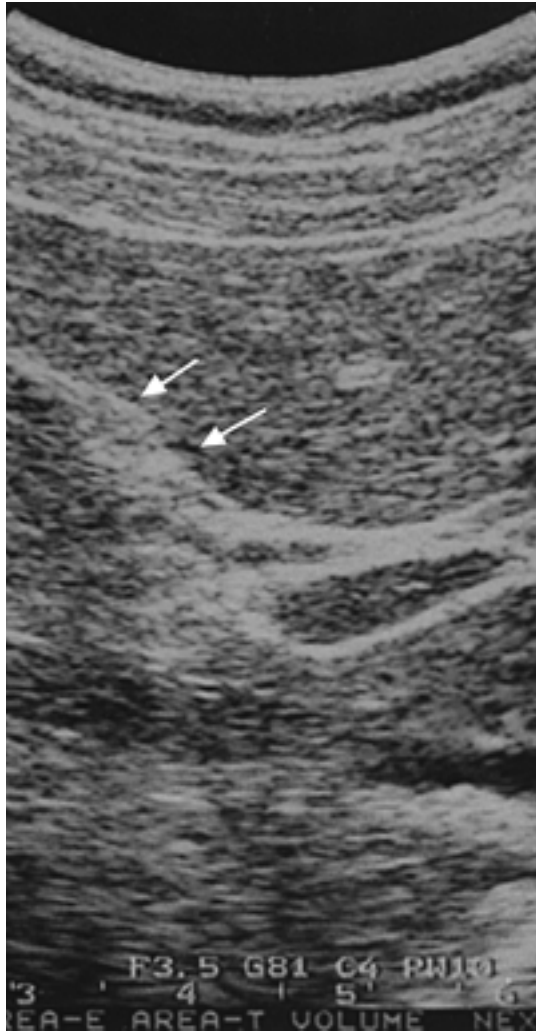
Abdominal ultrasonography shows no luminal organ corresponding to the gallbladder in the gallbladder fossa, while high echo areas alone are observed (arrow).
